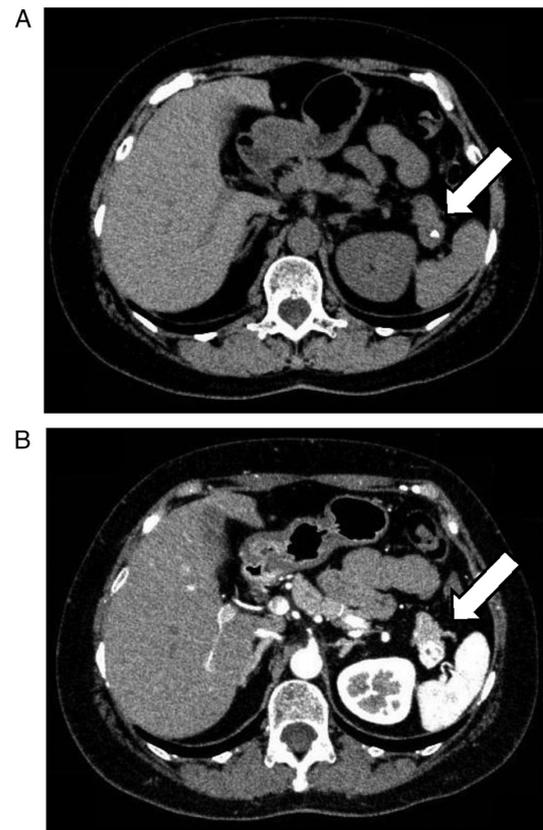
Abdominal plain (A) and contrast-enhanced (B) computed tomography. A low-density mass with calcification in the pancreatic tail (white arrows).
